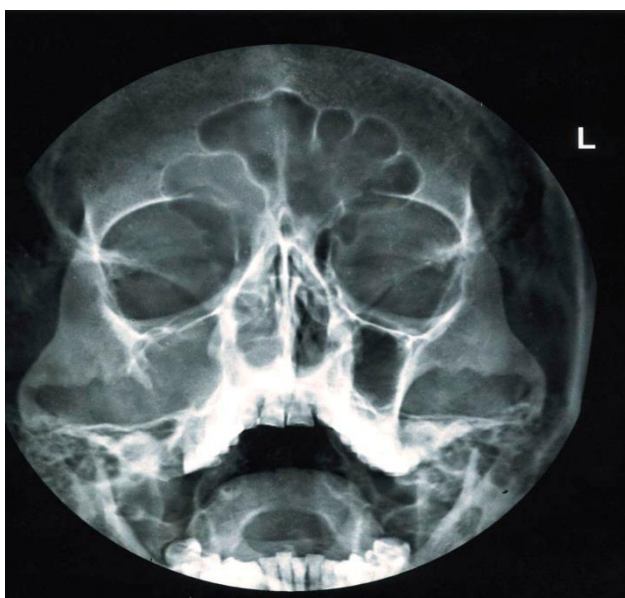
Photograph showing multiloculated radiolucent lesion of ameloblastoma in X-ray.
